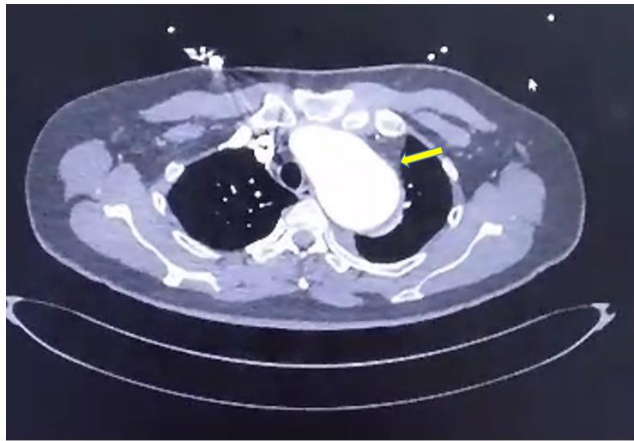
axial view of CTA: Yellow arrow: Arch of aorta aneurysm
